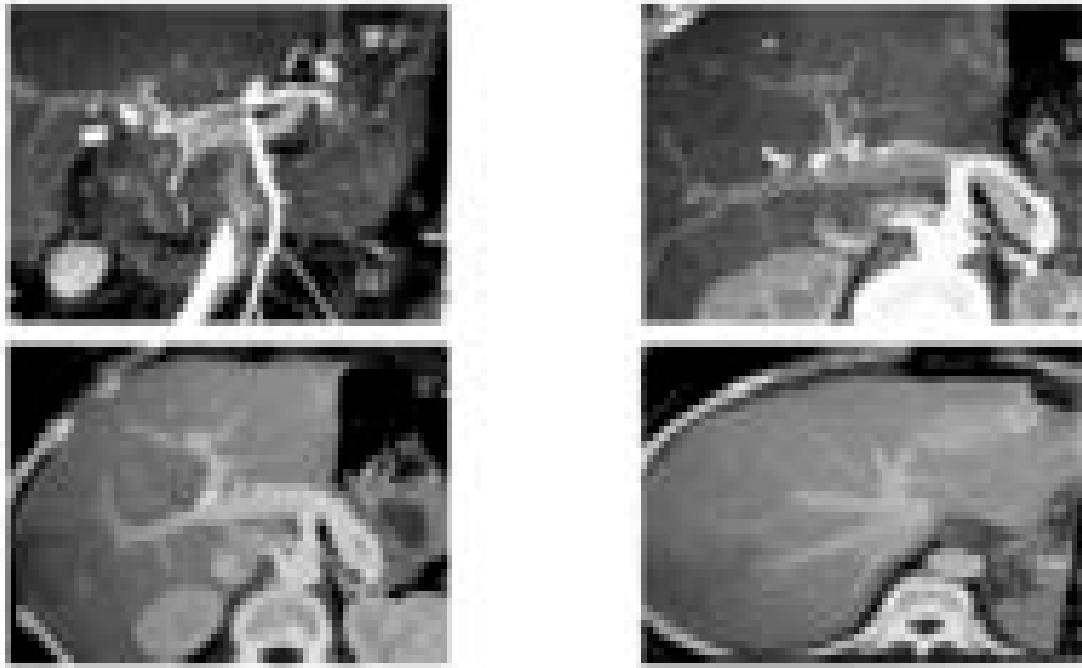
CTA reconstruction images showing hepatic arterial injury, normal hepatic veins and portal vein.
